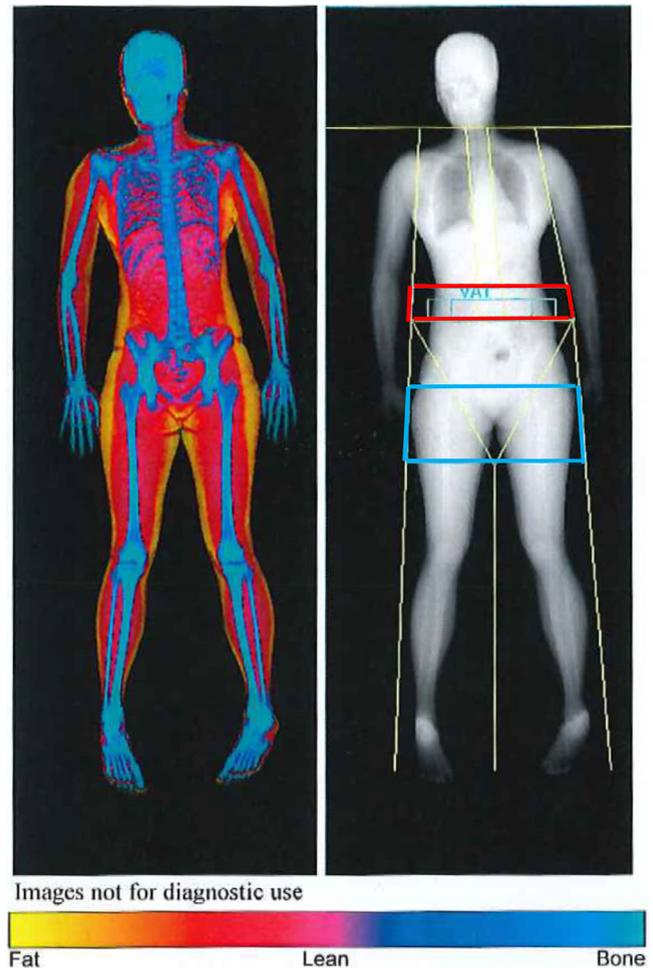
Dual-energy x-ray absorptiometry (DXA) scan showing demarcations between body regions. A, android; G, gynoid.
